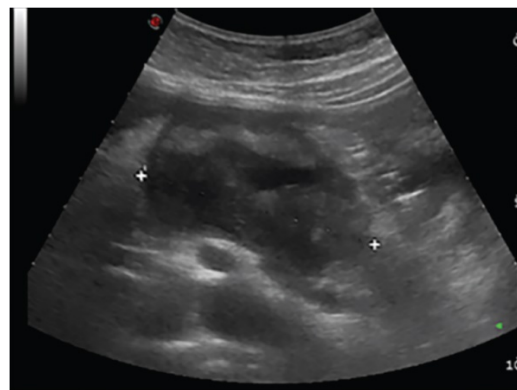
Abdominal ultrasonography (external compression)
